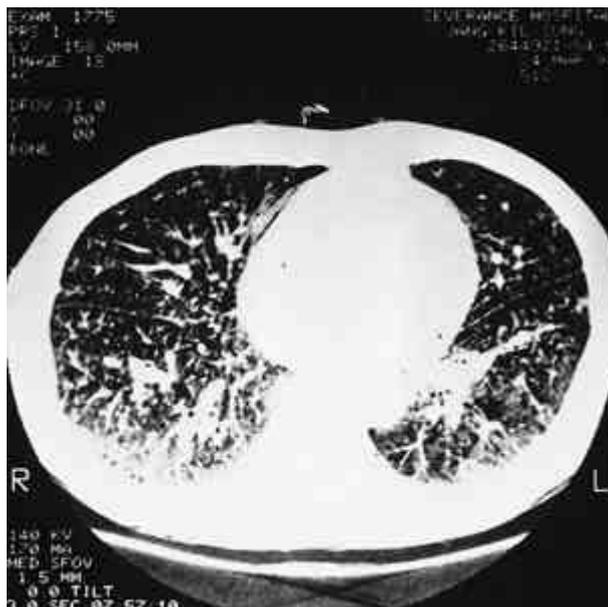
Chest CT scan shows multifocal areas of increased patch densities predominantly on the subpleural area and diffuse bronchial wall thickenings on both lungs.
